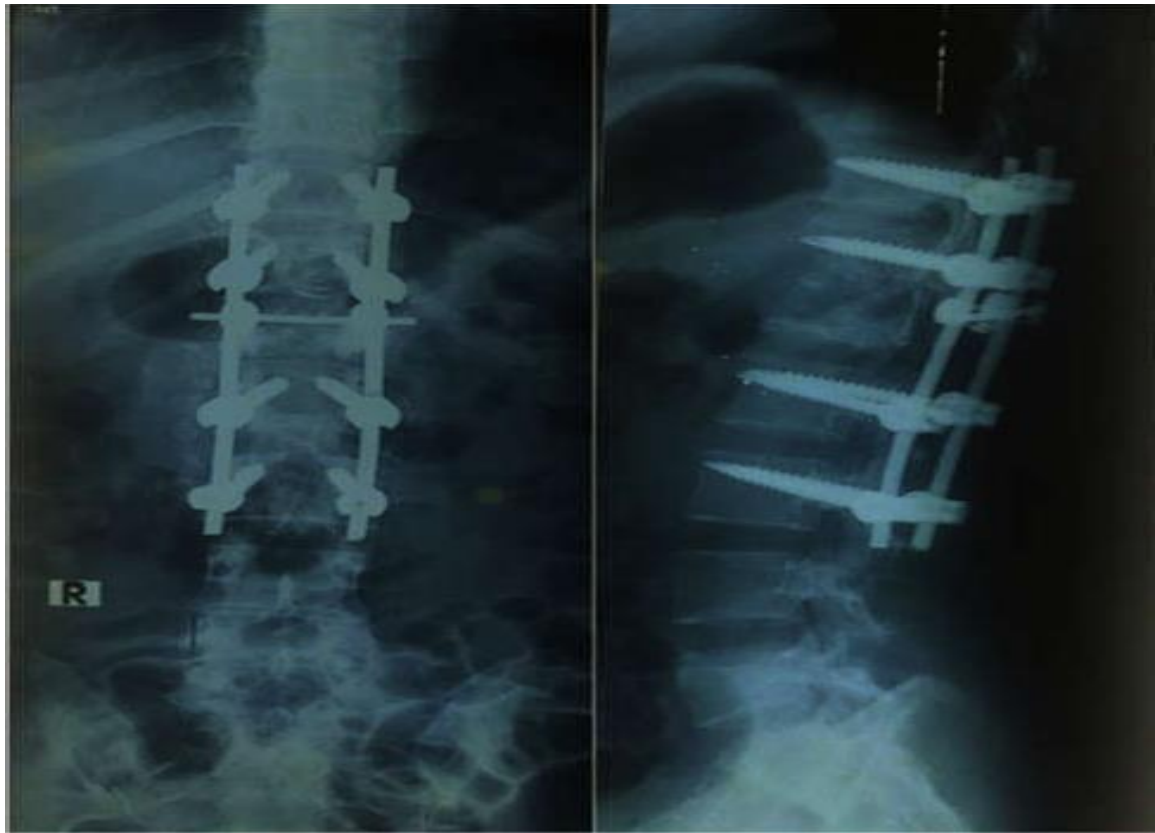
Post-operative (after 1 month of PSO) X-ray D/L spine AP and Lateral view showing proper implant position with correction of kyphosis.
